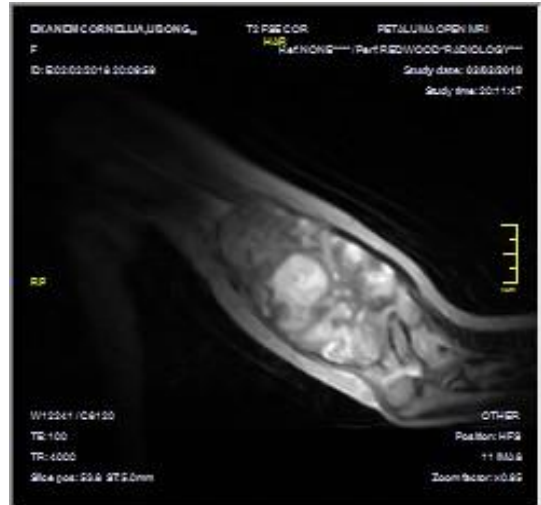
Coronal view MRI of the left arm.
